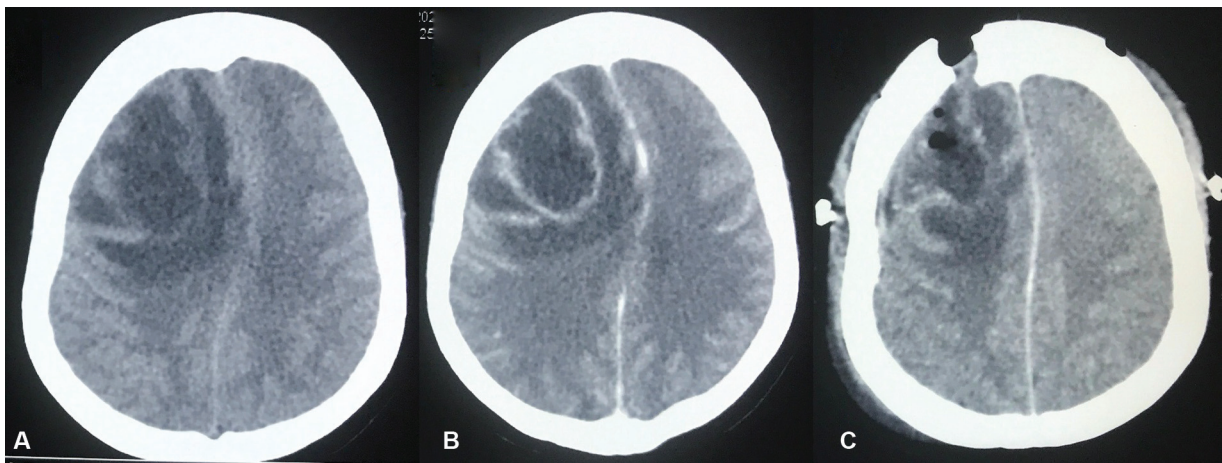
(A) Plain computed tomography (CT) head showing right frontal hypodense area with peripheral isodense rim. (B) Contrast CT head showing right frontal hypodense area with peripheral rim enhancement suggestive of abscess. (C) Postoperative contrast CT head showing excision of right frontal lobe abscess with postoperative changes.
